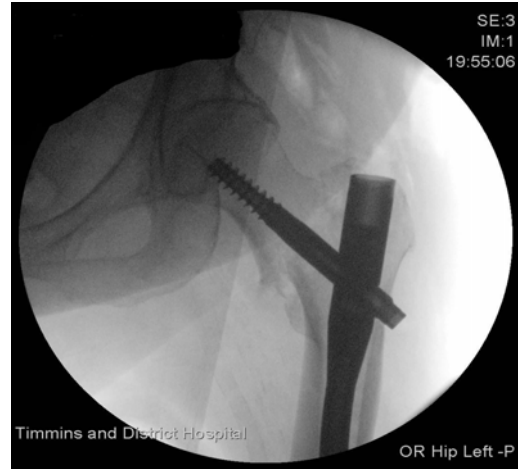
Post-operative X-ray showing fixation of the fracture with the trochanteric nail fixation system.
